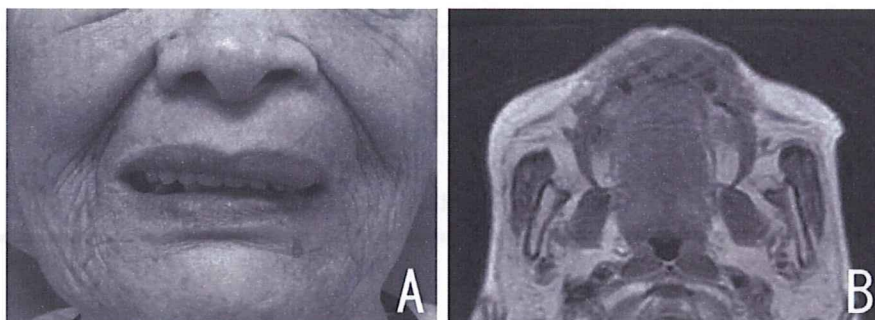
(A) 12 months after treatment, the tumor mass had markedly decreased in size and the patient could wear full dentures and eat without difficulty. (B) There were no apparent high-signal areas on T2-weighted (fat-suppressed) images.
